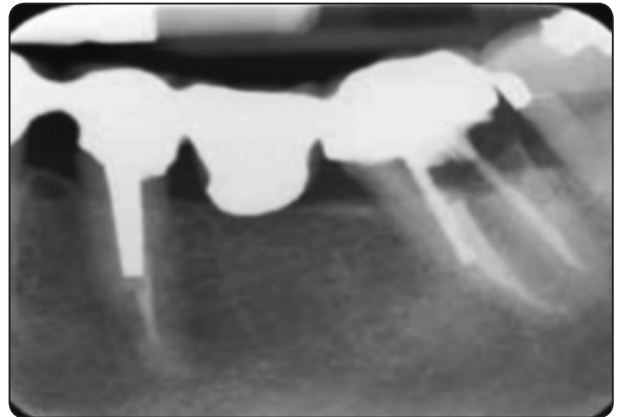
Preoperative radiograph showing missing lower first molar.
